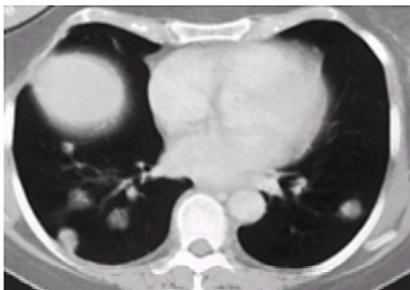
Multiple bilateral rheumatoid nodules in the lower lung zones. Cavitation is not seen clearly in this computed tomographic image, even though one-third of the nodules cavitate.
